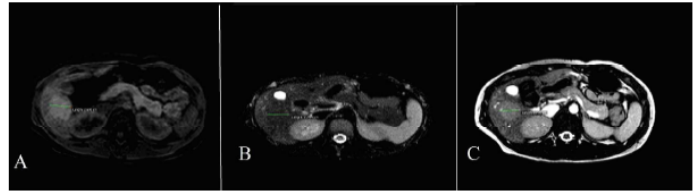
MRI Imaging of the abdomen, axial views. A) T1 weighted pre-contrastographic phase showing a spontaneously hyperintense nodule (green line), located in the V-VI segment, the biggest out of more than 10 detected in the right lobe. B) Fat-suppressed, T2-weighted image showing hypointense nodule. C) Balanced Turbo Field Echo sequence showing slightly hyperintense nodule.
